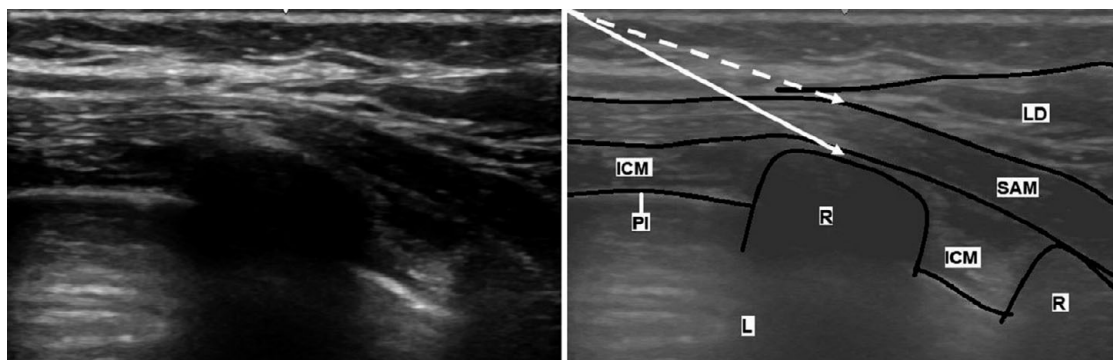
Ultrasound appearance of the serratus anterior plane block, showing serratus anterior muscle (SAM), latissimus dorsi (LD), intercostal muscle (ICM), rib (R), pleura (PI) and lung (L).
